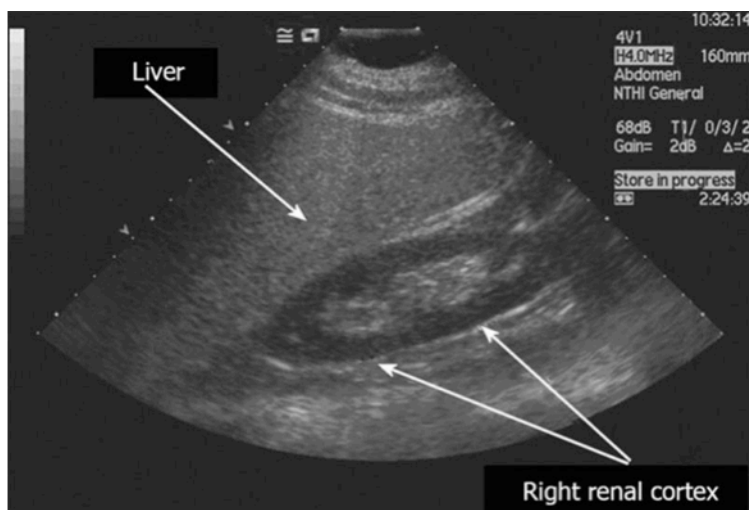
Ultrasound image with steatotic liver and normal kidney parenchyma.
